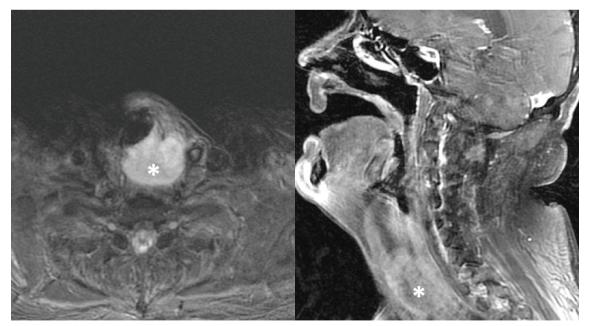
Magnetic resonance imaging of the neck revealed a tumor (asterisk) at thyroid gland level which had invaded the left dorsal aspect of the trachea and possibly the left lobe of the thyroid gland.
